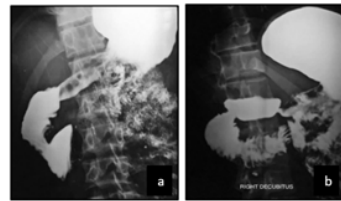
14 Y/F, c/o abdominal pain and vomitings, Barium meal spot radiographs showing vertical impression over 3rd part of duodenum (a) that is relieved with right decubitus position (b).
